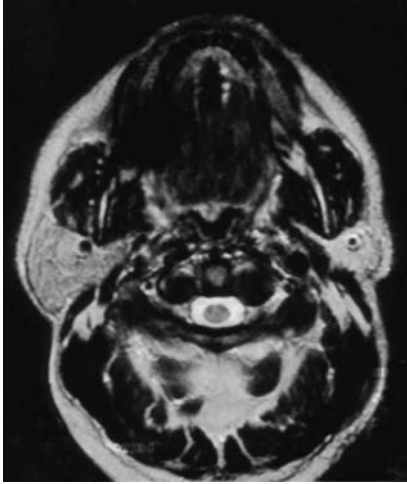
Magnetic resonance imaging scan showing a patient with an enlarged parotid gland due to sialosis and hypoplasia of the contralateral gland.
